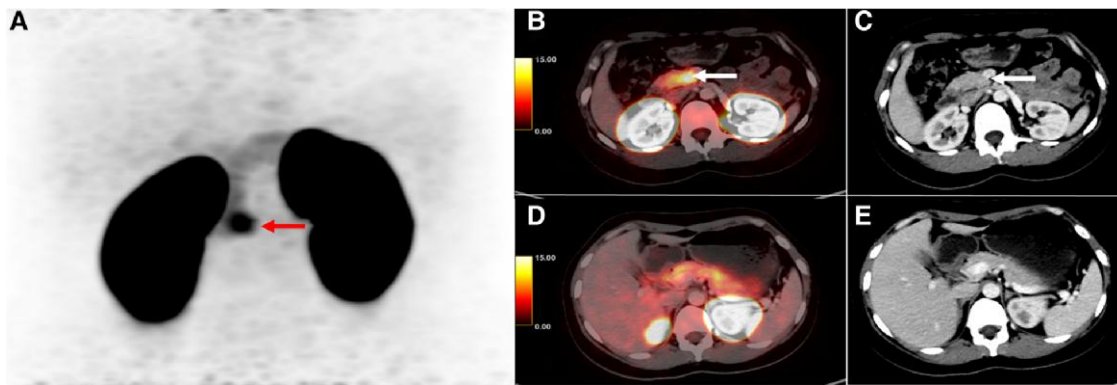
Maximum intensity projection (MIP) image of regional ⁶⁸Ga-exendin PET (A) showing focal tracer uptake in the region of the uncinate process of pancreas with mild diffuse uptake in the rest of the pancreas. Axial fused PET/CT image (B) showing focal tracer uptake (SUV_{max} 21.8) in the uncinate process of the pancreas with an inapparent lesion on corresponding CT image (C). Mild diffuse uptake was seen in the rest of the pancreas (D and E).
